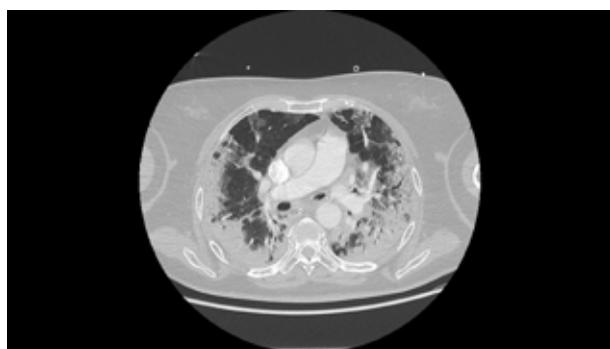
CT thorax scan demonstrating a severe lung involvement of COVID-19 infection. Ground glass, crazy paving and consolidations phenomena occur at the same time.
